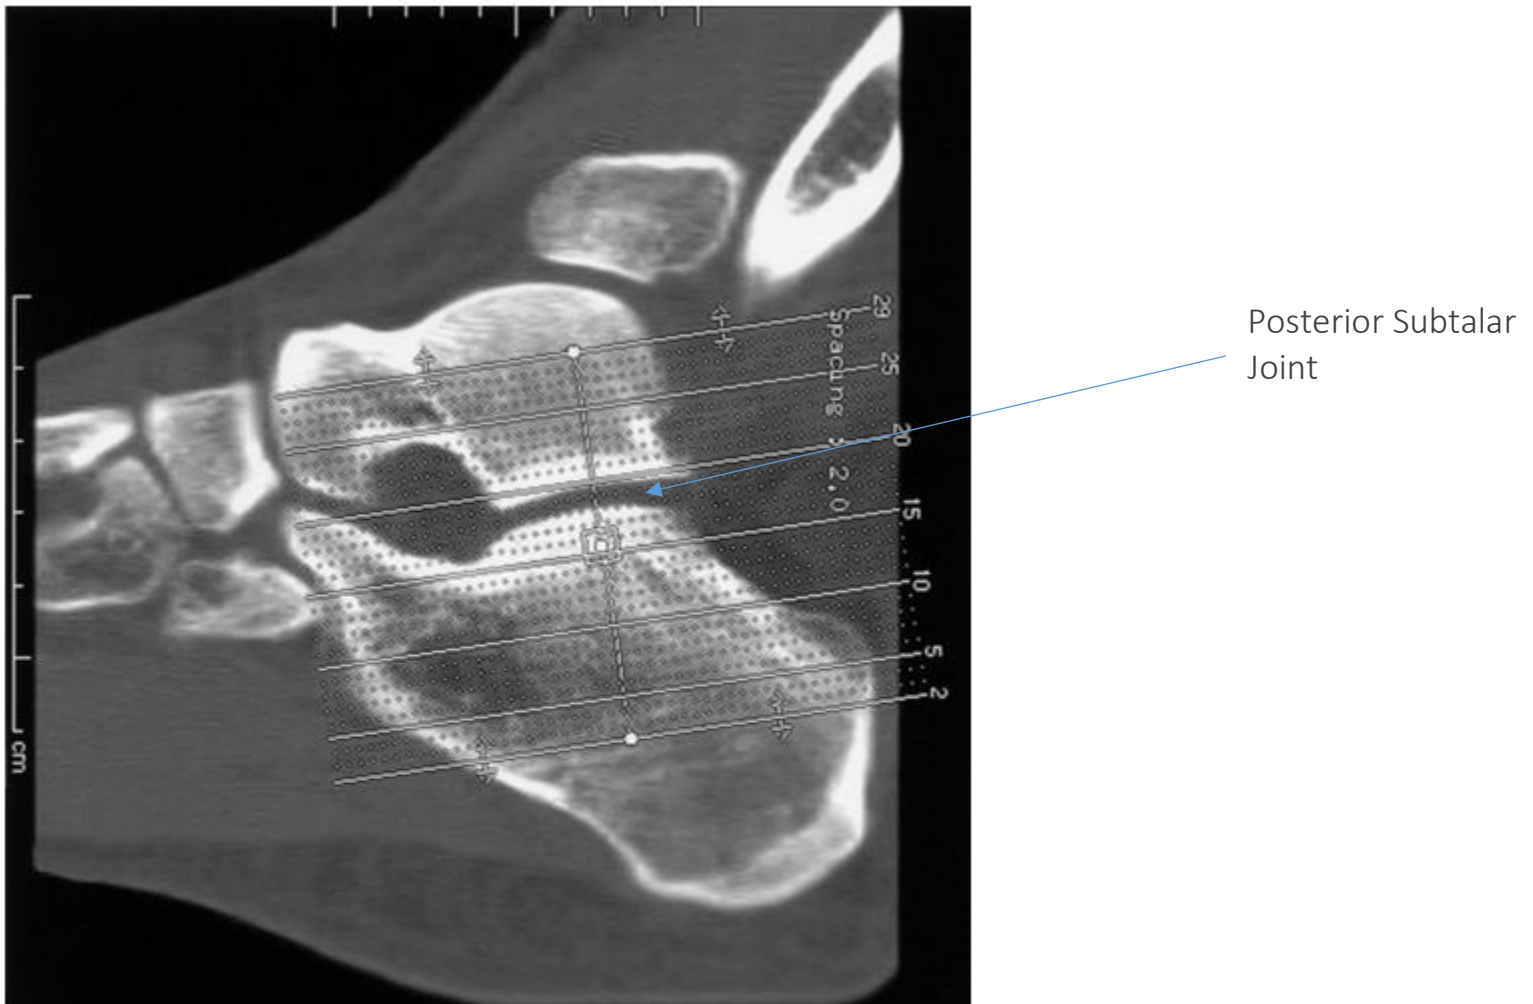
Optimal CT reformation planes for evaluation of calcaneal fractures. (a) Sagittal reformatted images of the calcaneus are prescribed off the axial images at the level of the ankle joint. (b) Coronal images are reformatted perpendicular to the sagittal images, also in reference to the ankle joint. (c, d) For fracture classification, particularly with the Sanders classification, we reformat our images parallel (c) and perpendicular (d) to the posterior facet off the sagittal reformatted images.
